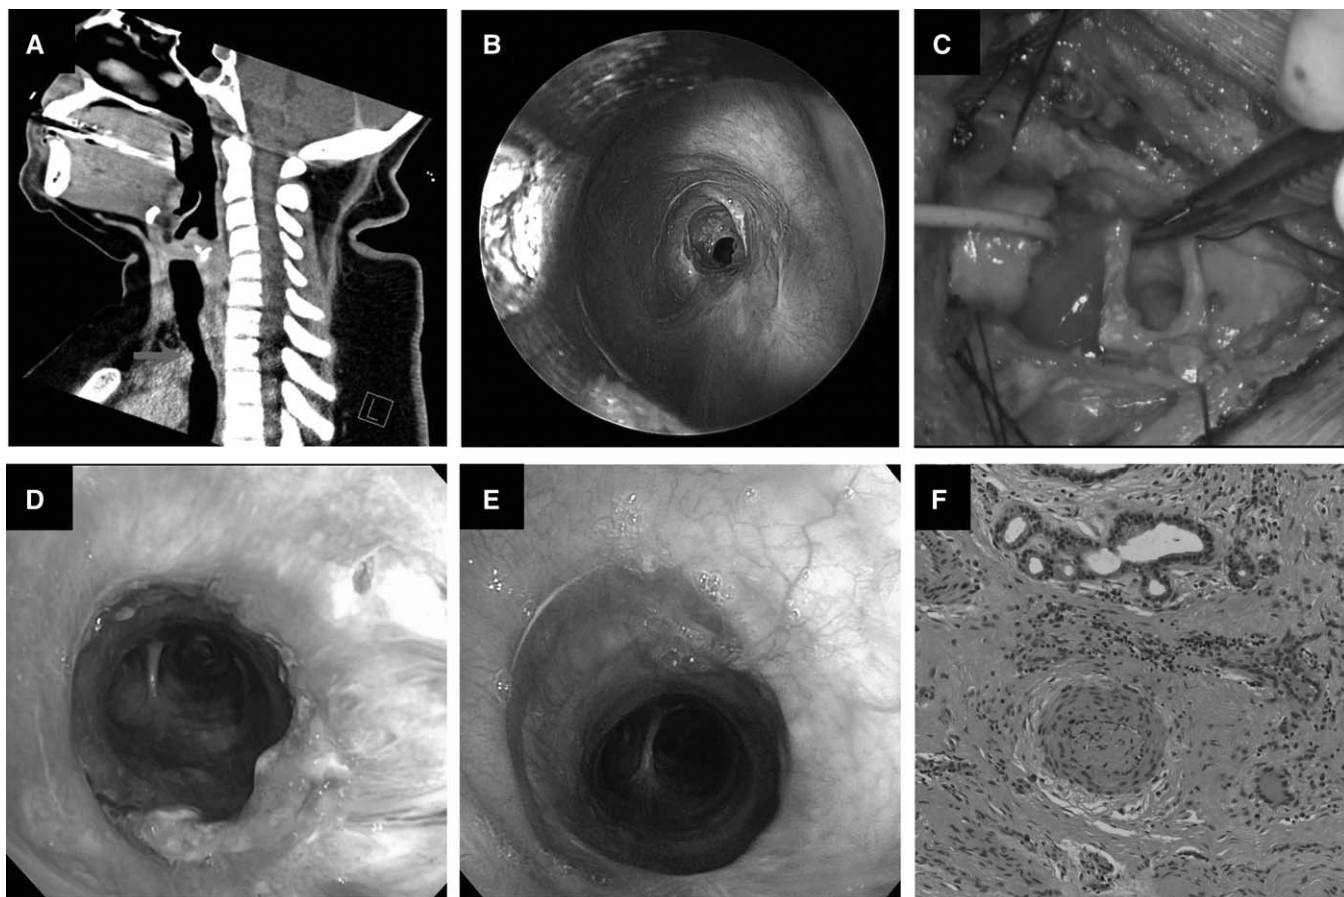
A 33-year-old female with COVID-19-related post-intubation tracheal stenosis. A, Sagittal computed tomography image showing stenosis of the distal cervical trachea (red arrow). B, Bronchoscopic appearance of the stenosis. C, Intraoperative photo after resection of the stenotic tracheal segment with restoration of normal airway diameter, followed by primary anastomosis. D, Postoperative result 7 days after surgery with a patent airway. E, Bronchoscopic appearance ~8 weeks after surgery. F, Pathologic section of the tracheal wall at the site of the stenosis showing multiple microthrombi and dense fibrous scarring.
